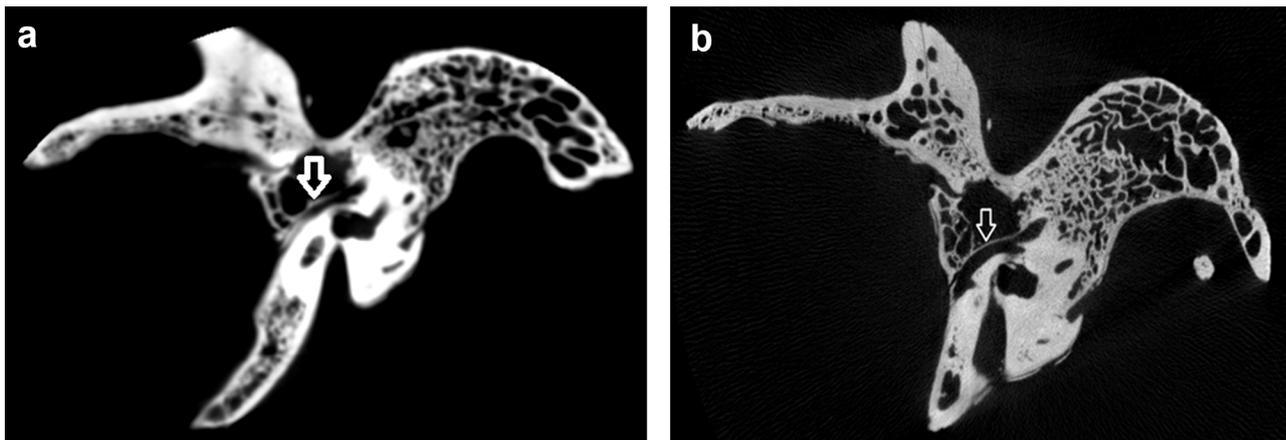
(a) CBCT view of the facial canal with dehiscence (Arrow show the bone structure covering the facial canal). (b) Micro-computed tomography image of the facial canal with intact bone structure of the same sample. (Arrow show the bone structure lining the facial canal)
